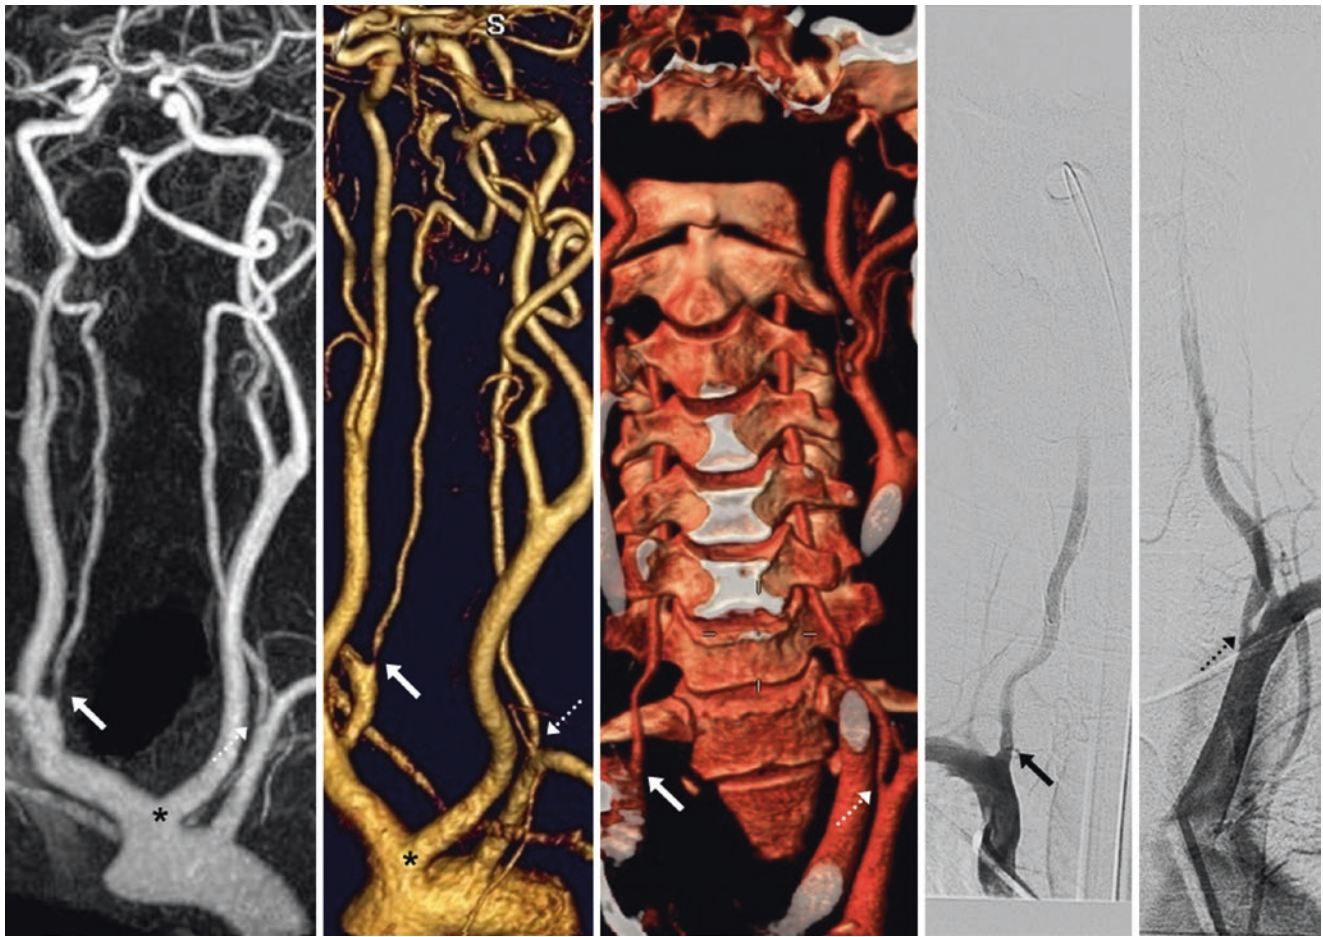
Pseudo-stenosis and true stenosis. In this 62-year-old, a right VA origin stenosis (arrows) was suspected on a CEMRA oblique AP view (left and left middle), but was not apparent on a CTA 3D VR AP view (middle). DSA found no stenosis (right middle), but a 60% stenosis of the left VA origin was found (dotted arrow, right). Note a common origin of the left common carotid artery and innominate artery (asterisks, left)
